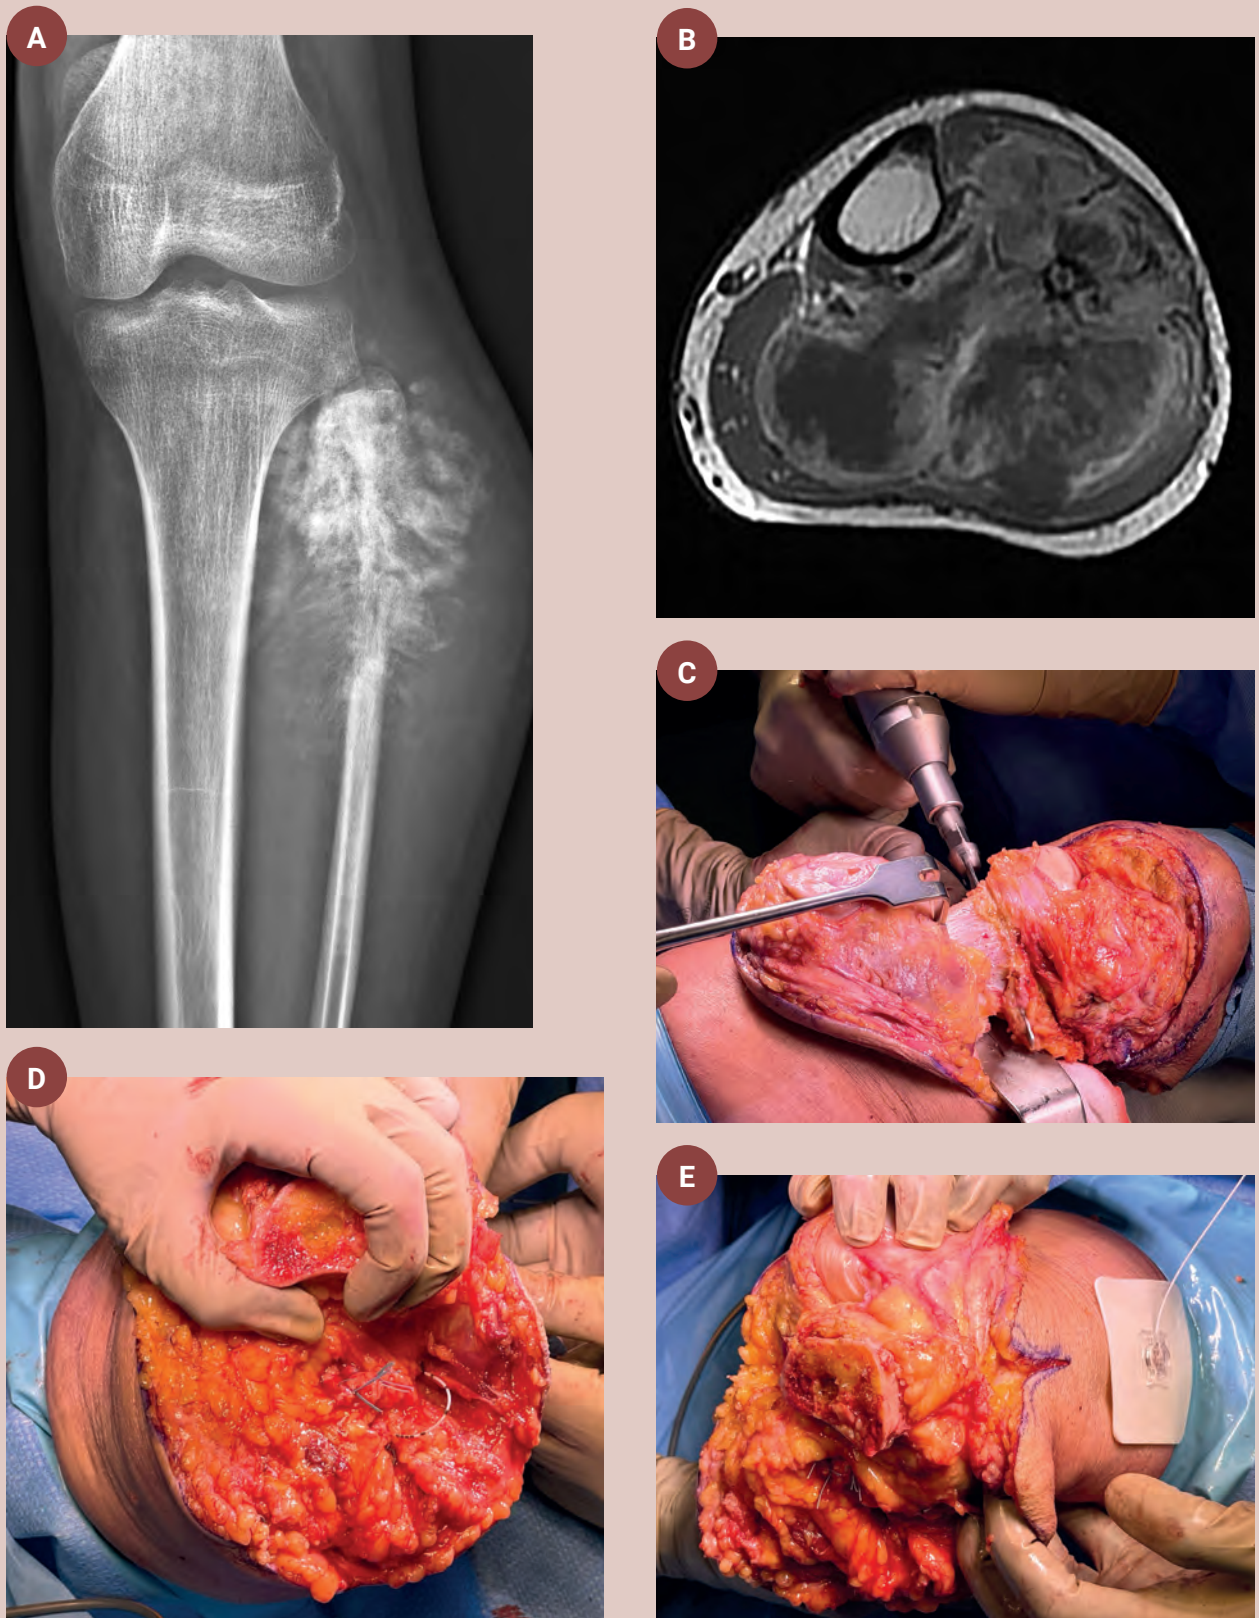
Anteroposterior radiograph (A) and T1 axial magnetic resonance imaging scan (B) of the proximal right fibula of an 18-year-old boy with osteosarcoma, treated with supracondylar amputation (C). Intraoperative photographs show the insertion of a small catheter into the transected sciatic nerve and its emergence from the lateral surface of the thigh via a percutaneous approach (D-E). →
